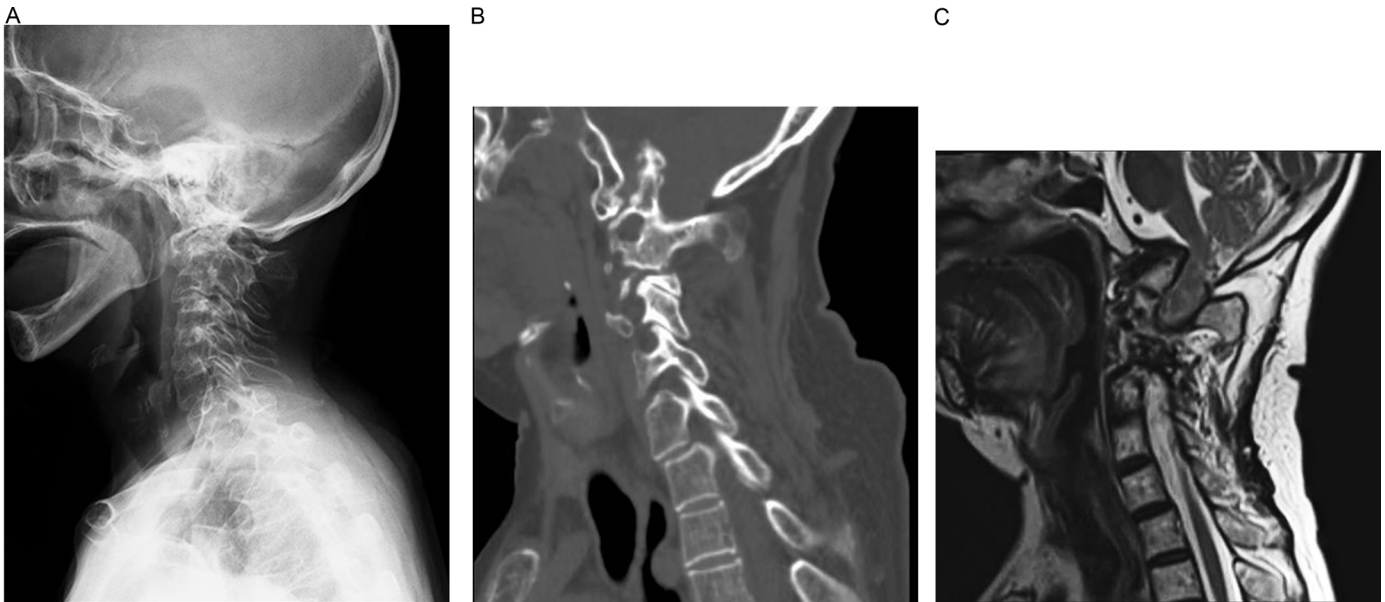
(A) A lateral cervical radiograph showing severe vertical subluxation. (B) A sagittal CT image demonstrating the upper migration of the odontoid process. The fusion of the clivus and C1 is also noted. (C) A T2-weighted sagittal MR image showing compression of the spinal cord with high-intensity signal changes at clivus level.
